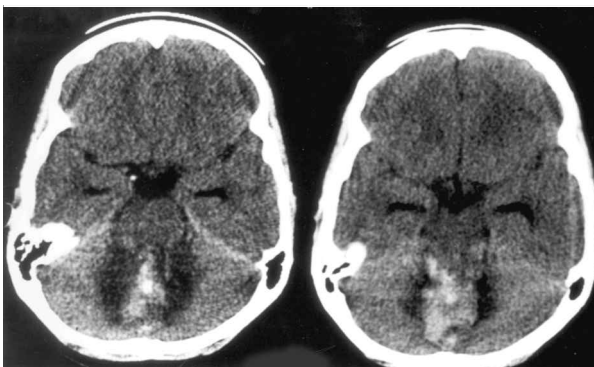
Enhanced CT scan of the posterior fossa showed high attenuation area due to cerebellar haemorrhage surrounded by low attenuation due to brain oedema. Prominent temporal horns, which indicates mild hydrocephalus.
